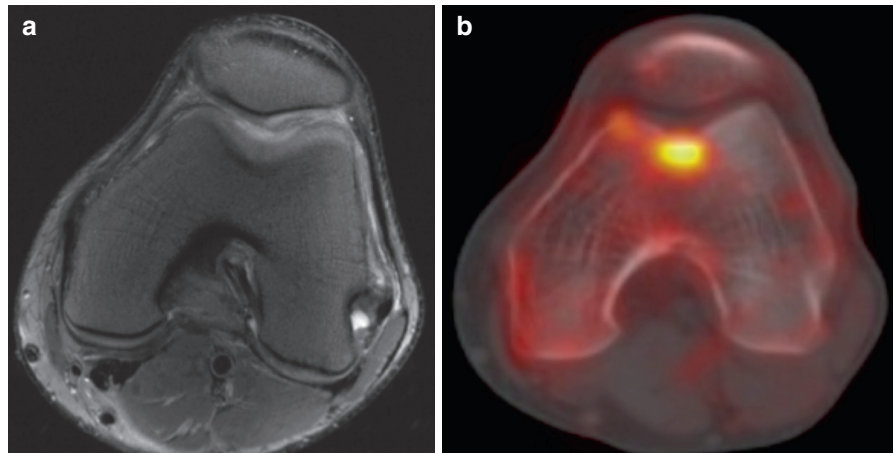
Axial MRI of chronic PF pain patient (a), showing no abnormalities within bone or cartilage of the PF joint. Corresponding PET hotspot in the same subject (b), indicating areas of high metabolic activity
